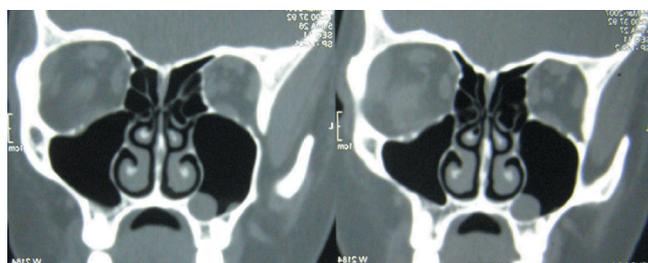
Plain CT paranasal sinuses -Coronal sections showing polypoidal mucosal thickening in the left maxillary sinus.
